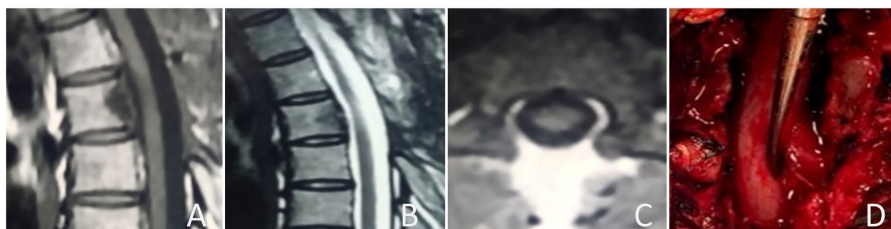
Post-operative MRI showing satisfactory decompression of the dural sac, shriveled hydatid cyst in sagittal view T1 in (A), T2 in (B and C). In (D) intraoperative appearance of the hydatid cyst after laminectomy; the left anterolateral cyst with aspiration of the contents of the cyst and excision of its membrane.
